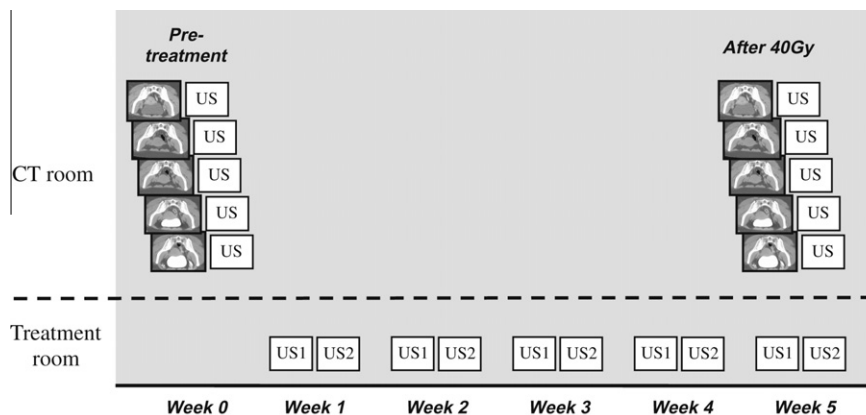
Protocols for (1) acquisition of pre-treatment (week 0) and after 40 Gy (week 5) variable bladder filling CT scans + corresponding US bladder volume measurements and (2) twice weekly in-room US measurements. For both CT-scanning sessions, all CT scans were acquired in an approximately 1 h interval.
